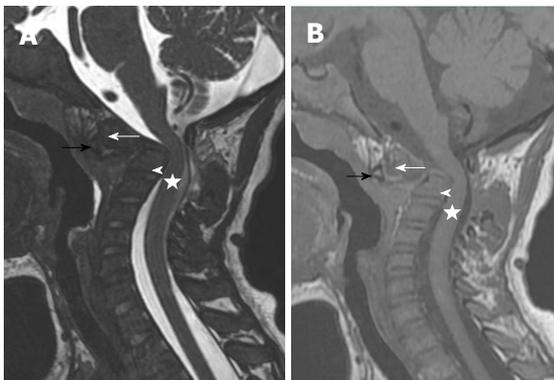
Six weeks follow-up after chemotherapy. Sagittal FSET2 (A), SET1 (B) magnetic resonance images: Displaced horizontal fracture of the dens responsible for a posterior wall recoil reducing cervical occipital hinge without intramedullary signal abnormality. Increase in the shrinkage of the cervical canal despite the regression of the infiltrative process. Black arrow: Anterior arch of C1; White arrow: The upper part of dens process; White arrowhead: The base of the dens; Star: Spinal cord.
